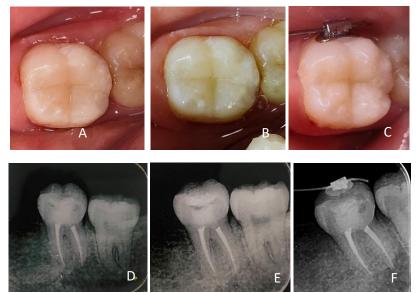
A Clinical picture of teeth during 1 month follow up. B Clinical picture of teeth during 6 month follow up. C Clinical picture of teeth during 1 year follow up. D Periapical radiograph of teeth during 1 month follow up. E Periapical radiograph of teeth during 6 month follow up. F Periapical radiograph of teeth during 1 year follow up
